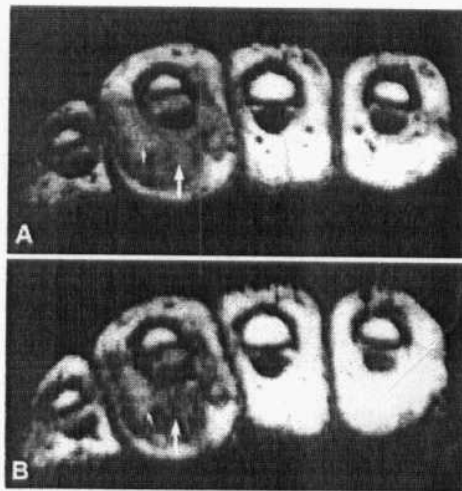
(A) giant cell tumor of the tendon sheath (ie, extraarticular pigmented villonodular synovitis; large arrows) demonstrates low signal intensity on axial (A) intermediate-weighted and (B) T2-weighted images. Minimal fluid signal intensity (short arrows) is seen (Quoted from Stoller and Brody, 1997).
